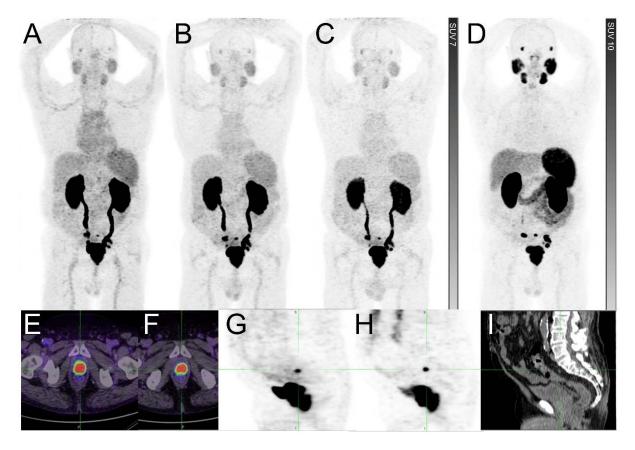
Primary staging of patient with Gleason 5+4=9 prostate adenocarcinoma and normal conventional imaging. ⁶⁸Ga-THP-PSMA MIP images at (A) 15 min, (B) 60 min and (C) 120 min, and (D) ⁶⁸Ga-HBED-PSMA 60 min MIP image comparison. Focal intense uptake is seen in the primary prostate tumor on (E) ⁶⁸Ga-THP-PSMA and (F) ⁶⁸Ga-HBED-PSMA PET/CT. Multiple sub-centimetre pelvic nodal metastases were visualized. (G) ⁶⁸Ga-THP-PSMA and (F) ⁶⁸Ga-PSMA-PSMA demonstrate focal uptake corresponding to (I) <5mm pre-sacral node on CT.
